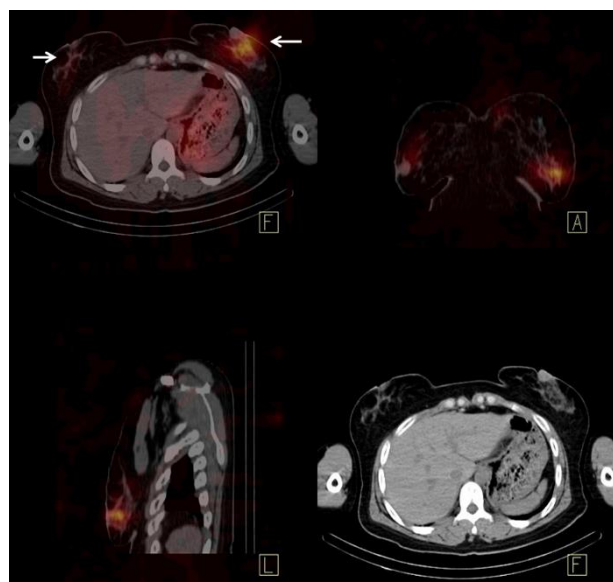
SPECT/CT of the chest also showed bilateral breast uptake (arrows).
